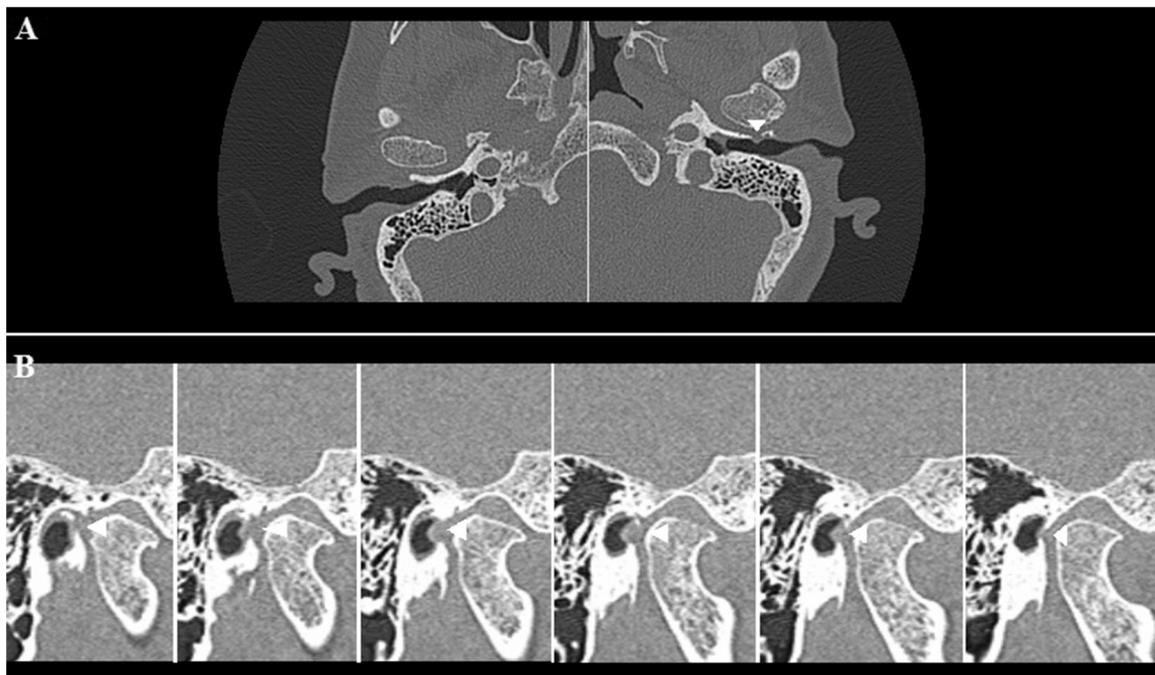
HRCT imaging of the temporal bone showing spontaneous temporomandibular joint herniation into the external auditory canal through foramen of Huschke: (A) axial plane; (B) sagittal plane.
